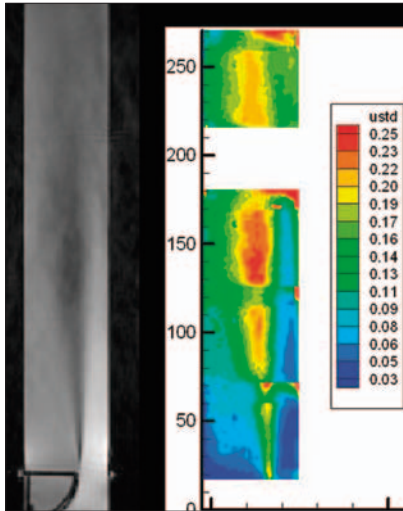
Contours of streamwise turbulent velocity fluctuation ( $u' = \sqrt{u'^2}$ , units m/s) measured with PIV (right) in a turbulent backward facing step flow. The gray scale MR image of the shear layer (left) shows the qualitative features of the flow structure (dark indicates higher turbulence).
